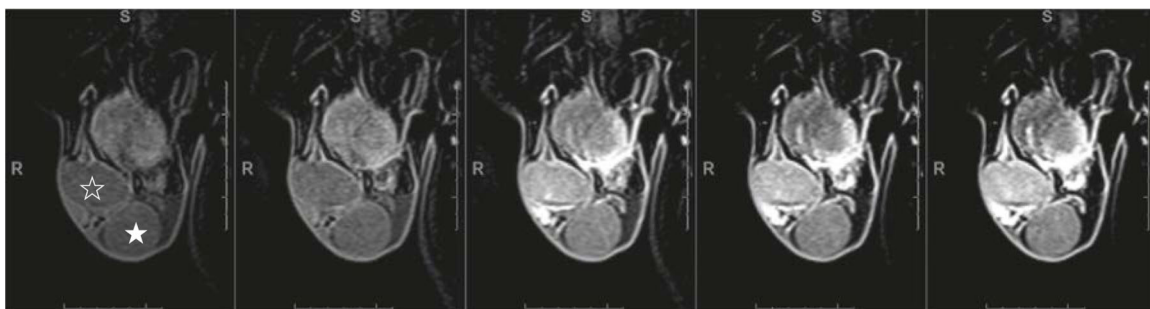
MRI of acute scrotum
